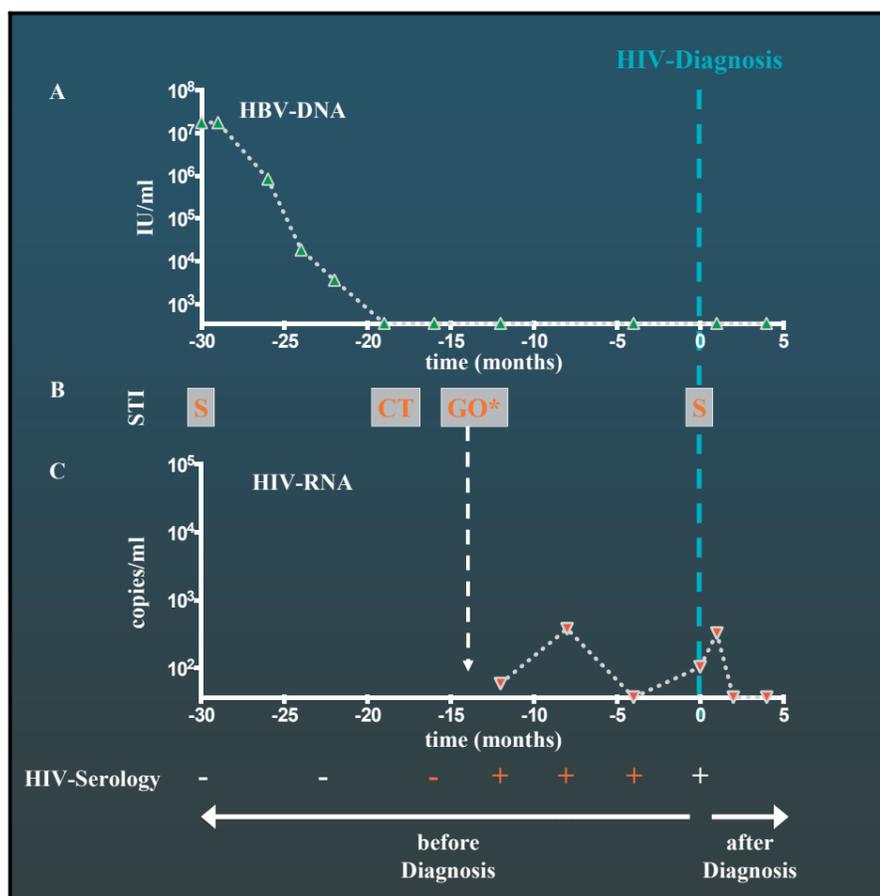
Quantification of HBV and HIV virus load and concomitant STI. A) Course of HBV-DNA levels. X-axis crosses y-axis at lower limit of detection (357 IU/ml). B) Concomitant STI; S: Syphilis; CT: Proctitis with *Chlamydia trachomatis*; GO: Gonorrhea. *Note that GO was diagnosed 2 months before HIV-serology became positive. C) HIV-RNA levels and HIV serology. Before HIV-diagnosis, HIV-RNA was quantified in frozen serum samples retrospectively. Orange HIV-Serology results identify retrospective analyses of frozen serum samples. X-axis crosses y-axis at lower limit of detection (37 copies/ml).
